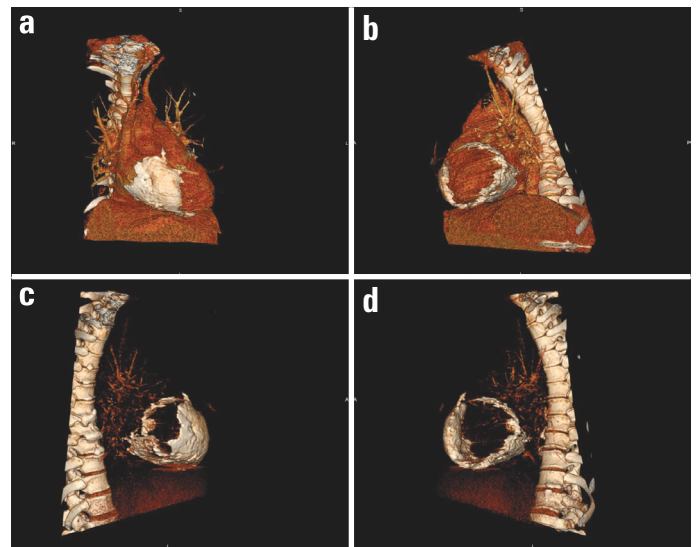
Cardiac multidetector computed tomography (a-d). Volume rendering reconstruction of cardiac structures showing severe pericardial calcification surrounding nearly both the ventricles and atria, resembling a trapped heart
